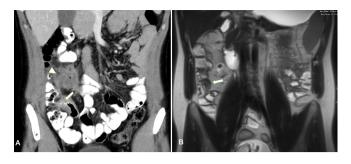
Thickening in the terminal ileum. A. Coronal CT with oral and IV contrast demonstrating thickening in the terminal ileum (white arrow) and an abscess superior to it (white arrowhead) from penetrating disease. B. MRI coronal T2 weighted sequence 2 years later demonstrating the thickening in the terminal ileum is significantly reduced (white arrow) and there is complete resolution of the previously demonstrated abscess. CT: computerized tomography; MRI: magnetic resonance imaging.
